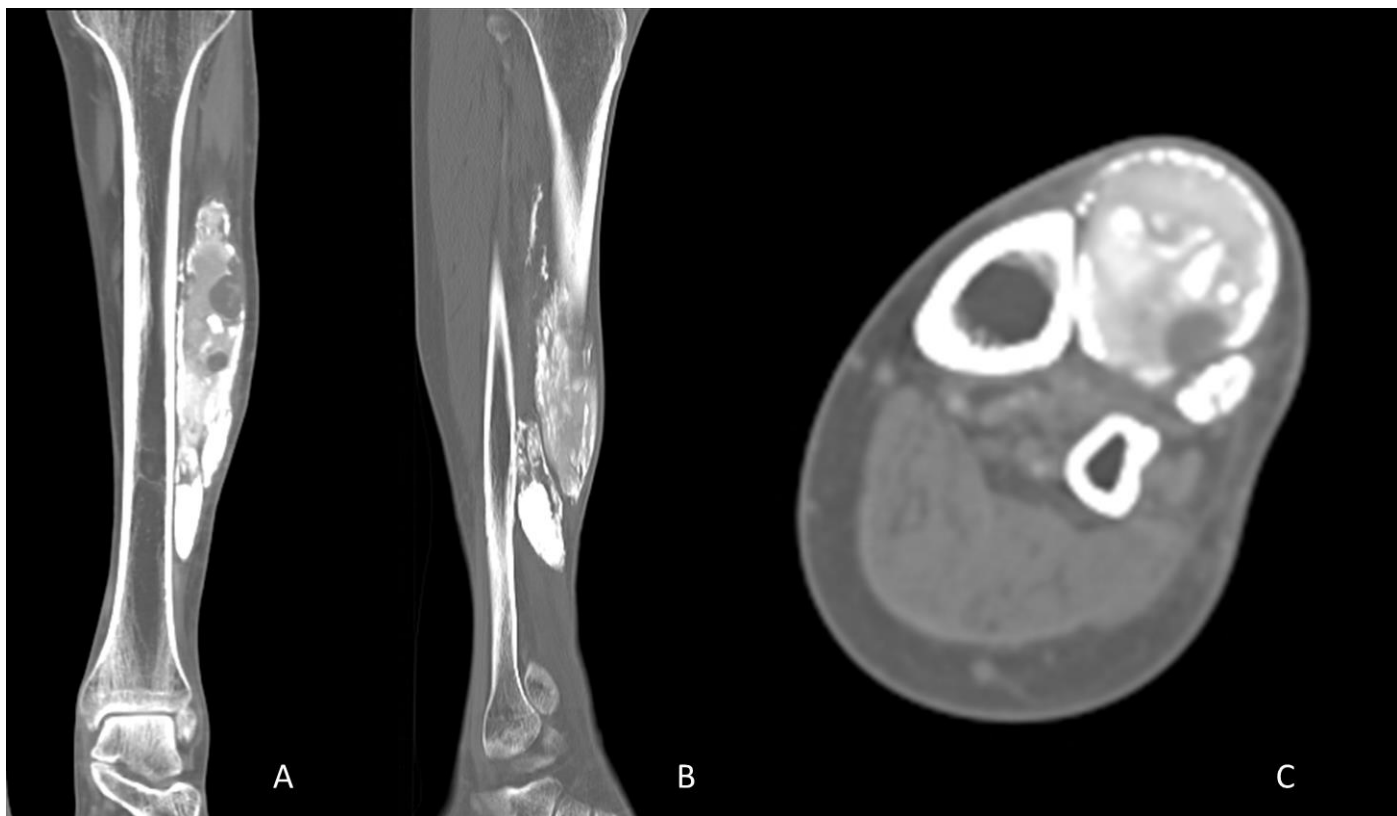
A 52-year-old male with chronic tophaceous gout. Coronal (A), sagittal (B) and axial (c) unenhanced CT images of the left leg performed nine years ago. Well-defined, rim calcified mass in the anterior compartment of the leg with internal ground-glass matrix. Though the mass comes into close proximity with the tibia, there were no changes detected in the underlying bones. Technical parameters: Siemens CT scanner, tube voltage 120kVp, tube current 40mA, slice thickness 3mm.
